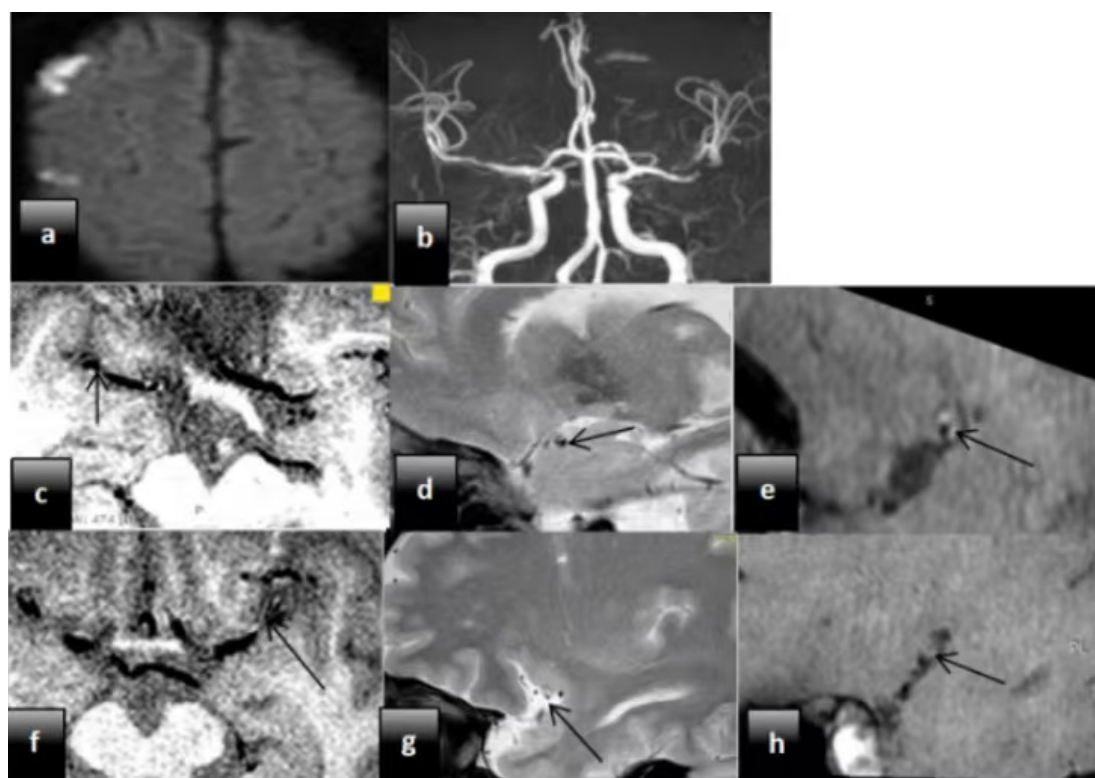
Representative cases: A 68-year-old man with acute left middle cerebral artery territory infarction with vulnerable plaque of bilateral middle cerebral arteries on HR-MRI.
